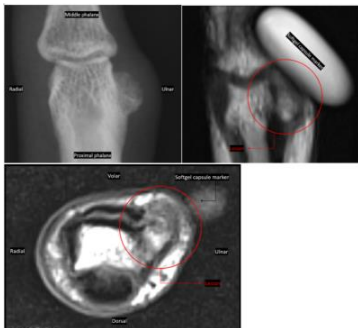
Radiographs and MRI
